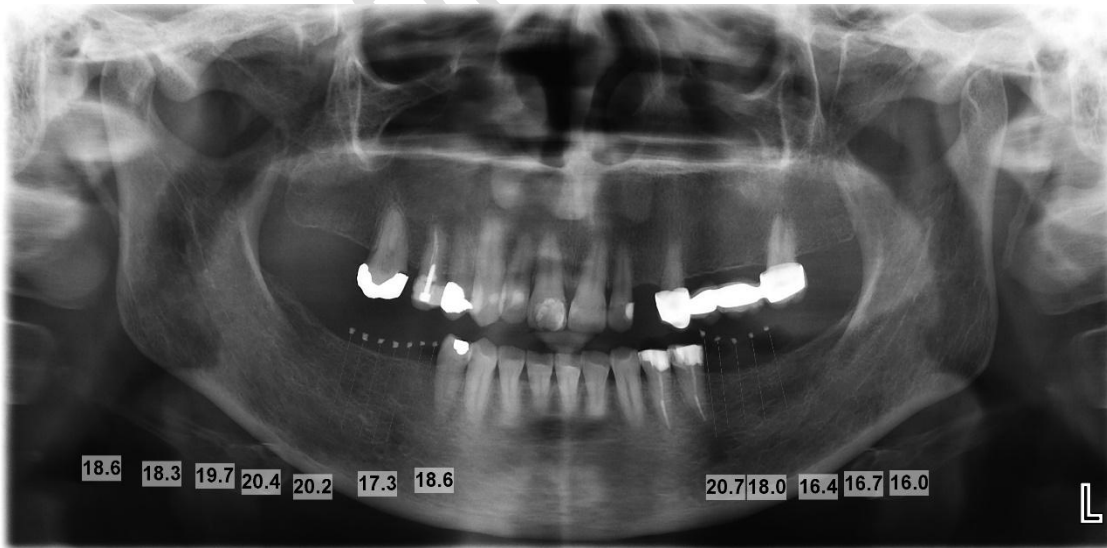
Panoramic radiography and measurement of specified points
